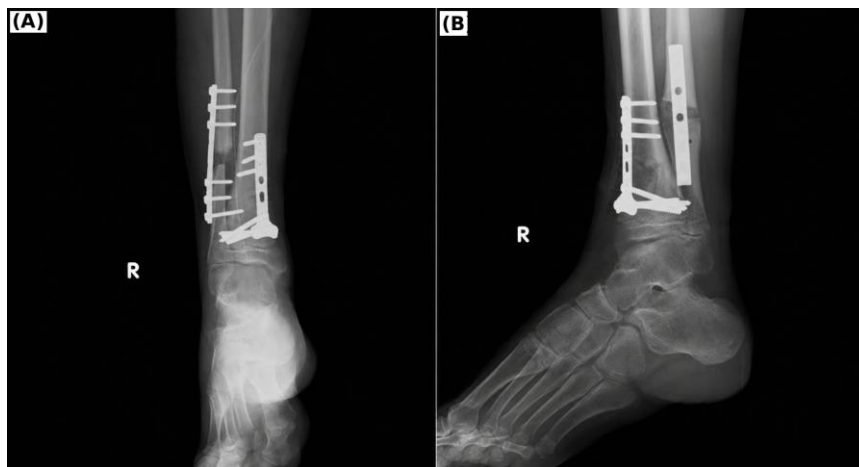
Immediate postoperative radiographs after single-stage double-level corrective osteotomy. (A) Anteroposterior and (B) lateral views demonstrating correction of the valgus deformity, with the distal fibula stabilized by a one-third tubular plate and the distal tibia by an anatomical T-locking plate.
